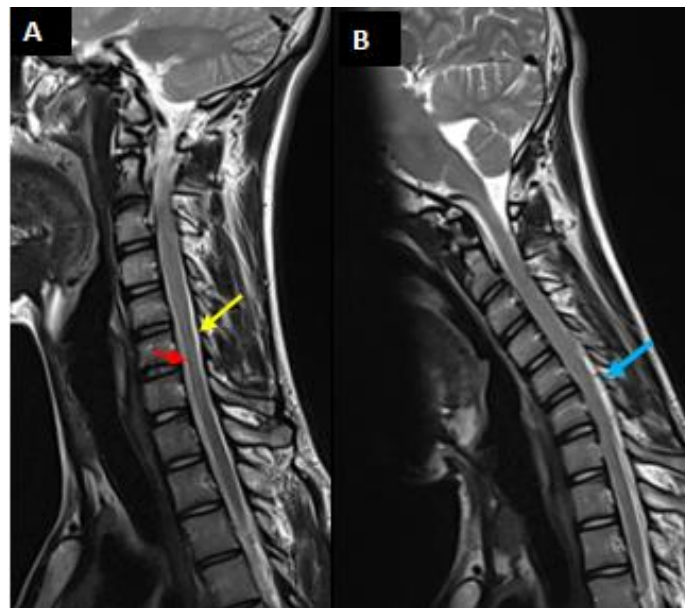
Sagittal T2 weighted MRI of the cervical spine in neutral (A) and neck flexion position (B). Neutral position (A) of the cervical spine show loss of cervical lordosis, focal atrophy of the lower cervical cord (yellow arrow) and associated increased T2 signal intensity of anterior horns were noted at C6/C7 levels (red arrow). Flexion position (B) demonstrates anterior shifting of the posterior dura, with subsequent cervical cord compression. The posterior epidural space was markedly enlarged (blue arrow).
